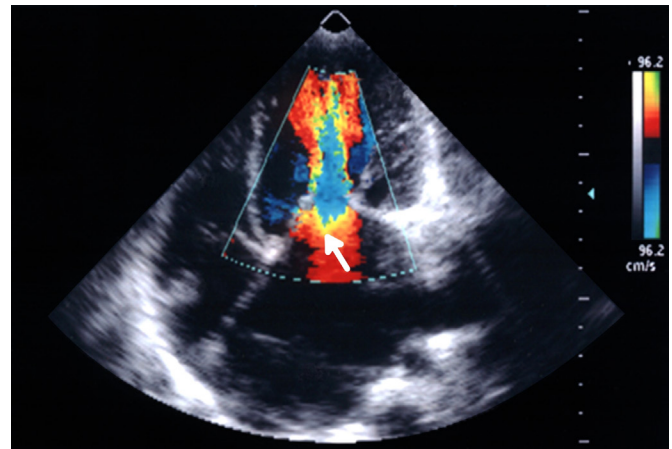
Echocardiogram. Apical four-chamber echocardiographic view of a patient with rheumatic mitral valve regurgitation (green color flow). Adapted from Echocardiogram Department, from Heart Institute (InCor), São Paulo, Brazil.
